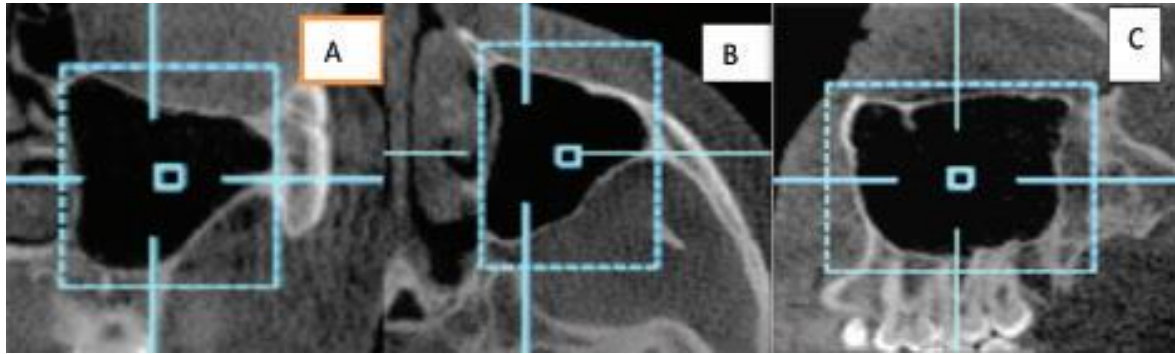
Cone beam CT; Magnification of outlined and selected Maxillary
